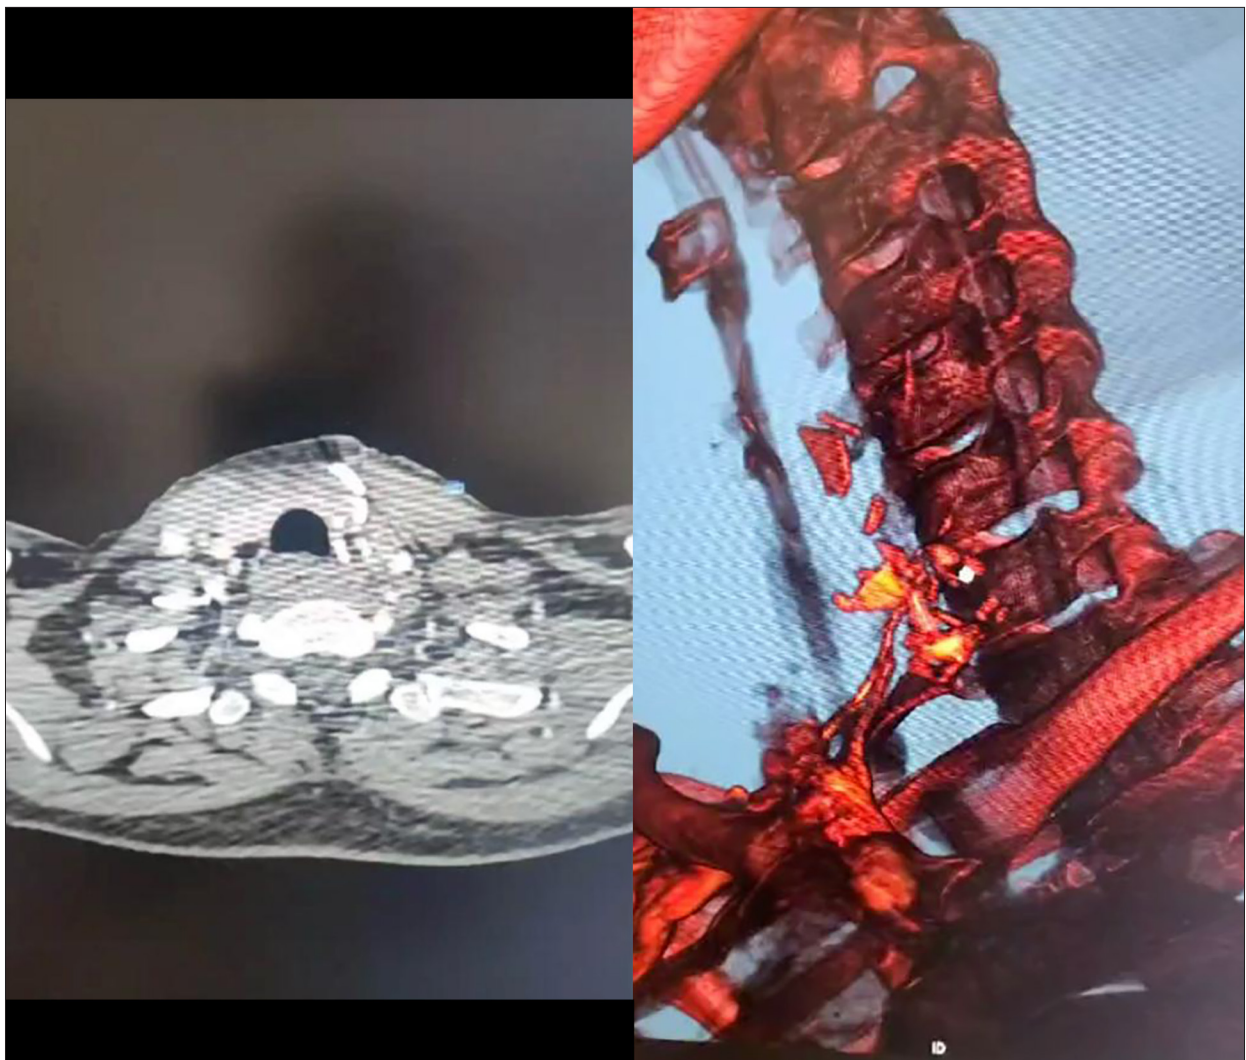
Computed tomography angiography image (left) and 3-dimensional reconstruction (right) showing multiple glass foreign bodies distributed throughout the cervical compartments.
